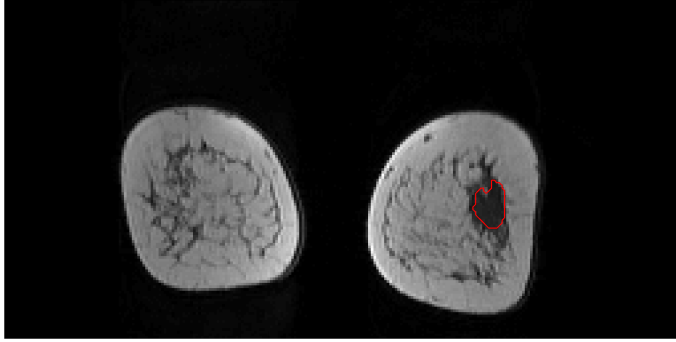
DCE-MRI slice in a pre-contrast image with a manual selected ROI (in red).
